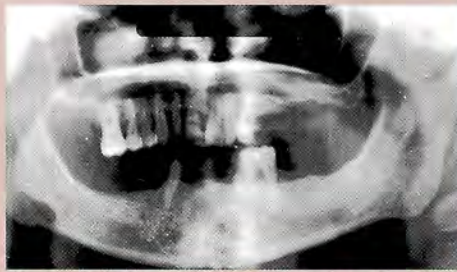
Preoperative clinical panoramic radiograph.
